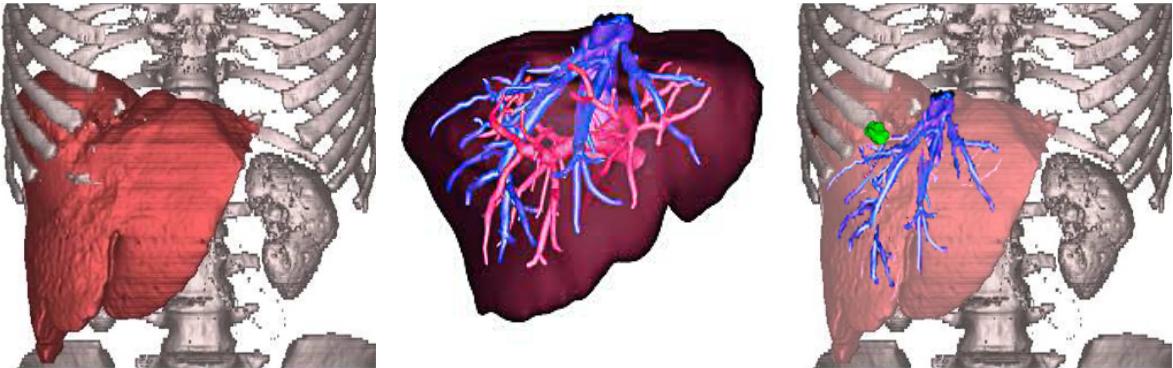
left: direct volume rendering of abdominal CT with highlighted liver [13], middle: vessel visualization of portal and hepatic tree described by Selle et al. [36], right: conceptual visualization of vessels and tumor (green) in the semi-transparent liver segmentation embedded in the CT rendering.
